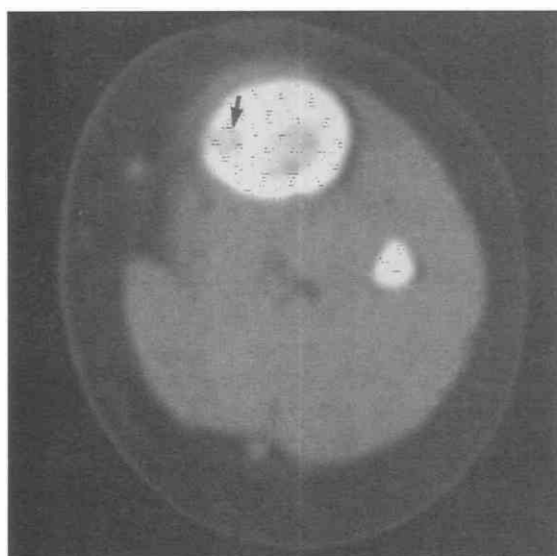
Osteoid osteoma. CT scan of the proximal left leg shows the nidus with central mineralization (arrow).
